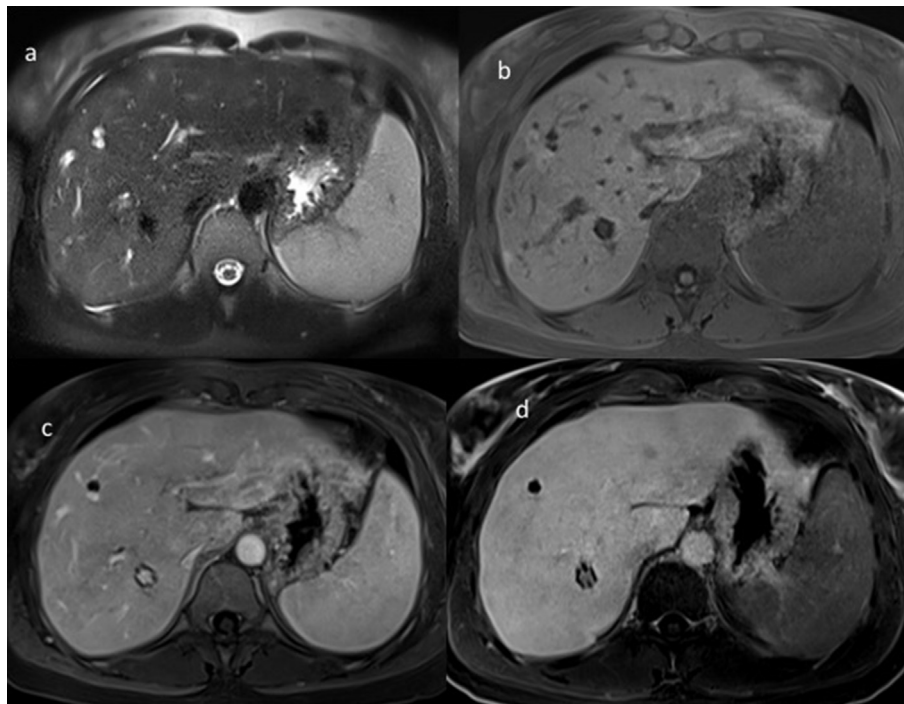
Liver MRI (A–D). A, at 18 months, STIR-T2w images showed a reduction of hyperintense periportal bands with poorly defined pseudonodular lesions in the right lobe; B, T1WI 2D-GE sequences showed a decrease in the hypointense bands-like of periportal fibrosis and a net reduction in the size of large regenerative lesions with remnants of periportal areas with poorly defined hyperintense signal. C, a significant reduction of contrast enhancement was observed around portal tracts and along the sides of periportal bands in the venous phase; D, no pathologic hypointense lesions were detected in the hepatobiliary phase.
